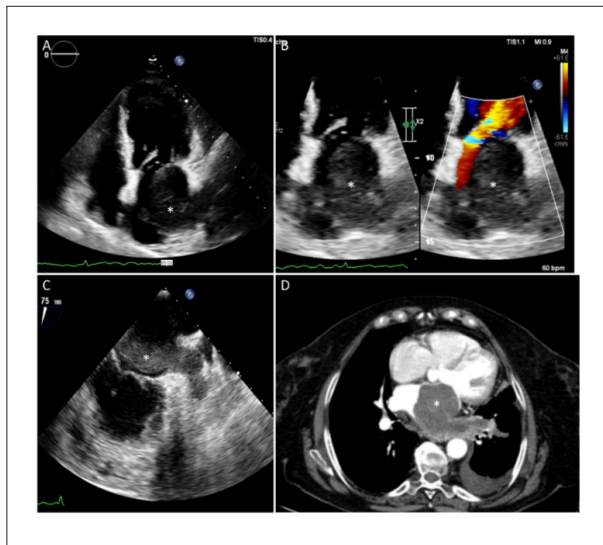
Echocardiography and computed tomography. (A) TTE four-chamber view revealing an oval mass (*) inside the LA. (B) zoom and color comparison of the LA and left ventricle inflow tract, demonstrating a diastolic pressure gradient. (C) TEE, raising the suspicion of left superior pulmonary vein and left atrial appendage involvement. (D) Thoracic CT scan confirming pulmonary vein invasion by the mass.
